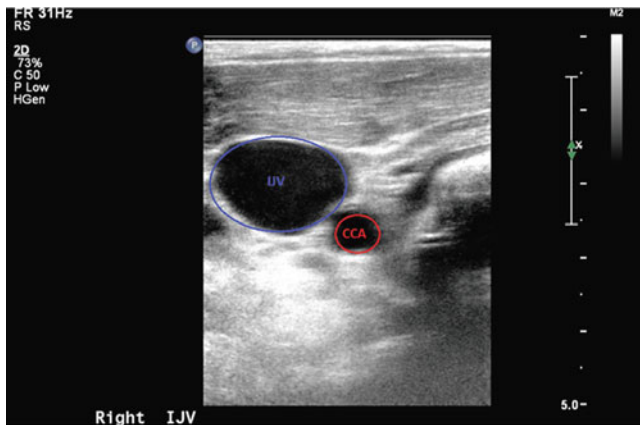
Ultrasound view of the internal jugular vein (IJV)
